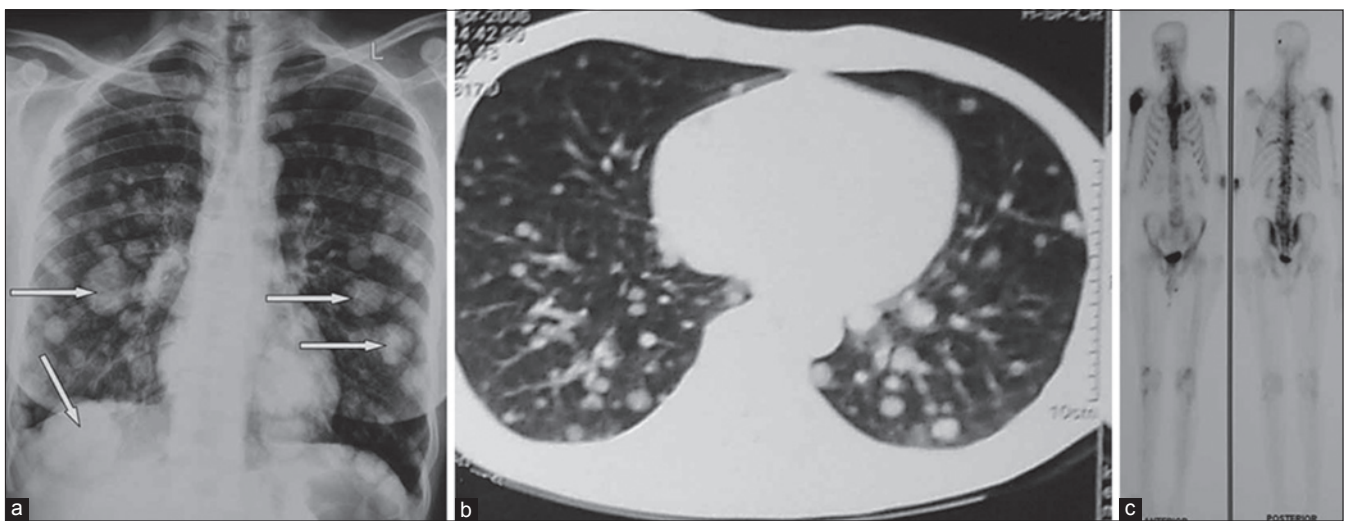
(a) Plain X-ray chest of a patient of osteosarcoma showing multiple metastatic lung nodules (b) CT scan (axial section) demonstrating multiple metastases in both lungs (c) Tc-99m bone scan of osteosarcoma in the proximal humerus with hot spot at this site and in spine, ribs and a focus in the skull bone
